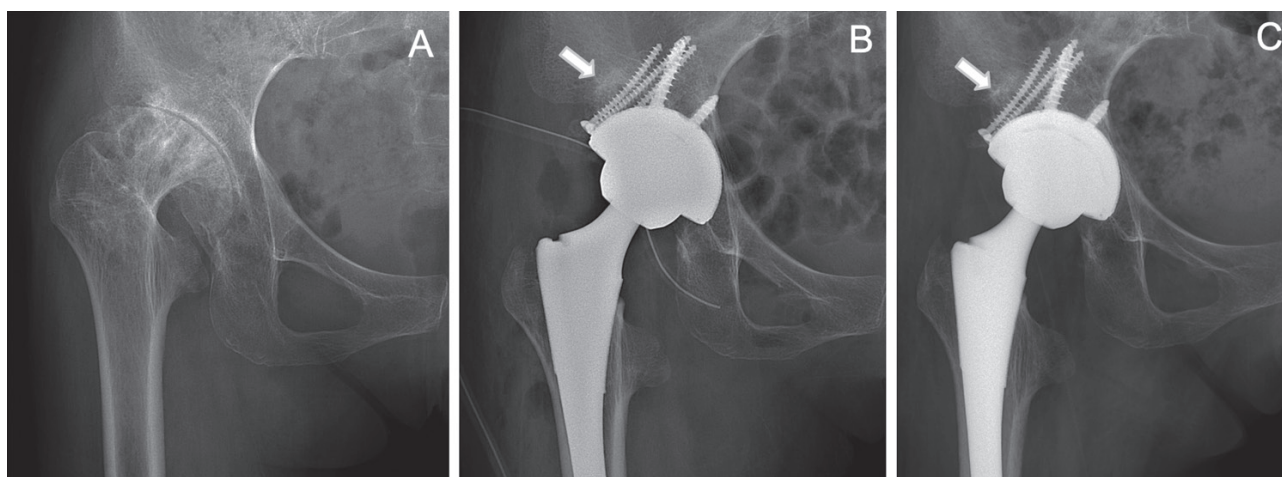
Radiographic evaluation: (A) Preoperative radiograph of a 53-year-old female patient with DDH. (B) Radiograph immediately after surgery. (C) Radiograph 3 years after operation. No signs of loosening was detected.
